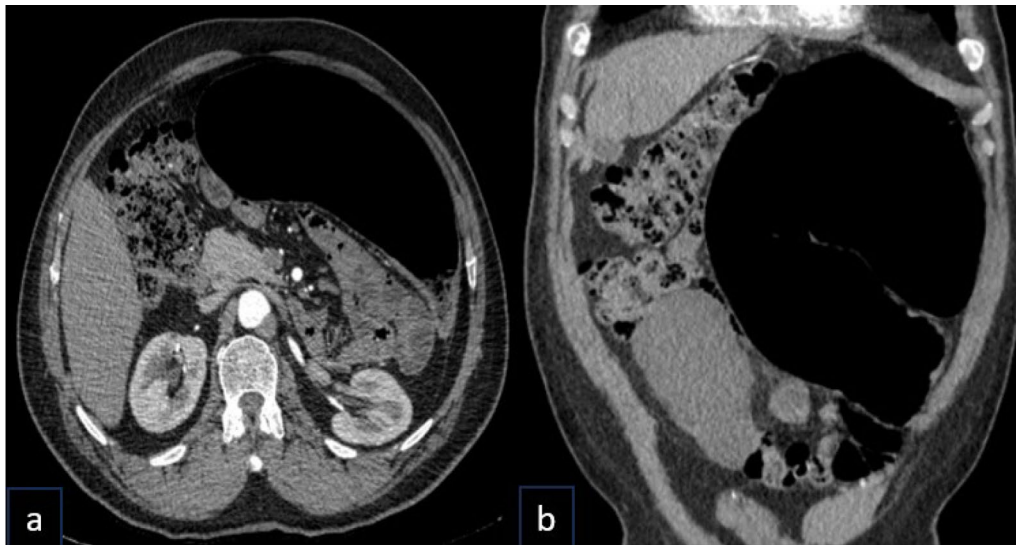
Post-contrast CT: a axial and b coronal images: dilated transverse colon and proximal descending colon
